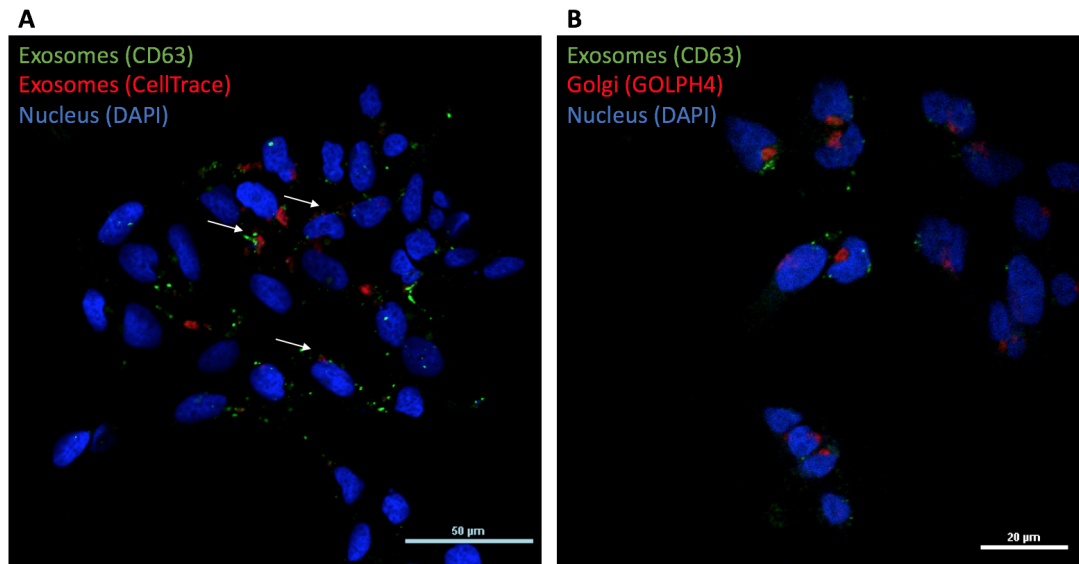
Biodistribution of CD63-labelled exosomes. A. SK-N-MC exosomes labelled with CT (red) or CD63 (green) after 4 h incubation with SK-N-MC cells. Arrows indicate areas where both exosome populations cluster nearby. Scale bar = 50 µm. B. CD63-labelled exosomes (green) after 4 h incubation with SK-N-MC cells, labelled with Golgi marker (GOLPH4, red). Scale bar = 20 µm.
